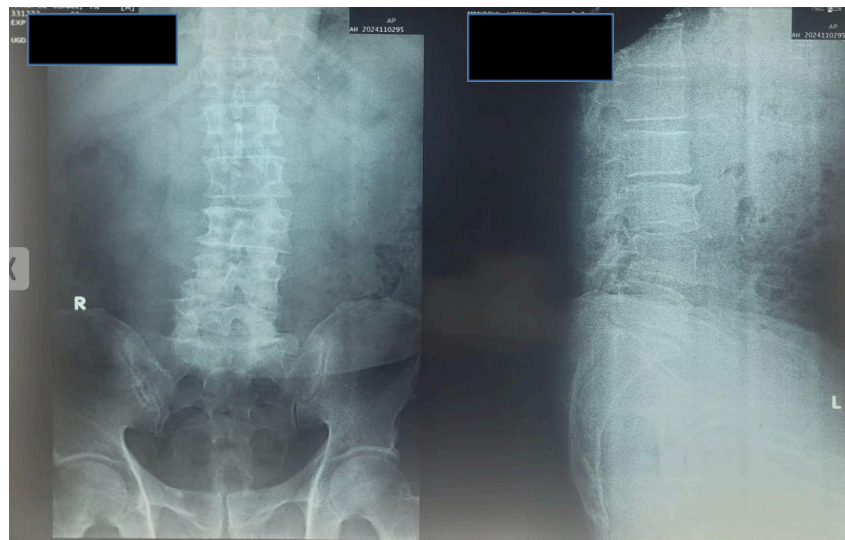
Lumbosacral X-ray*
